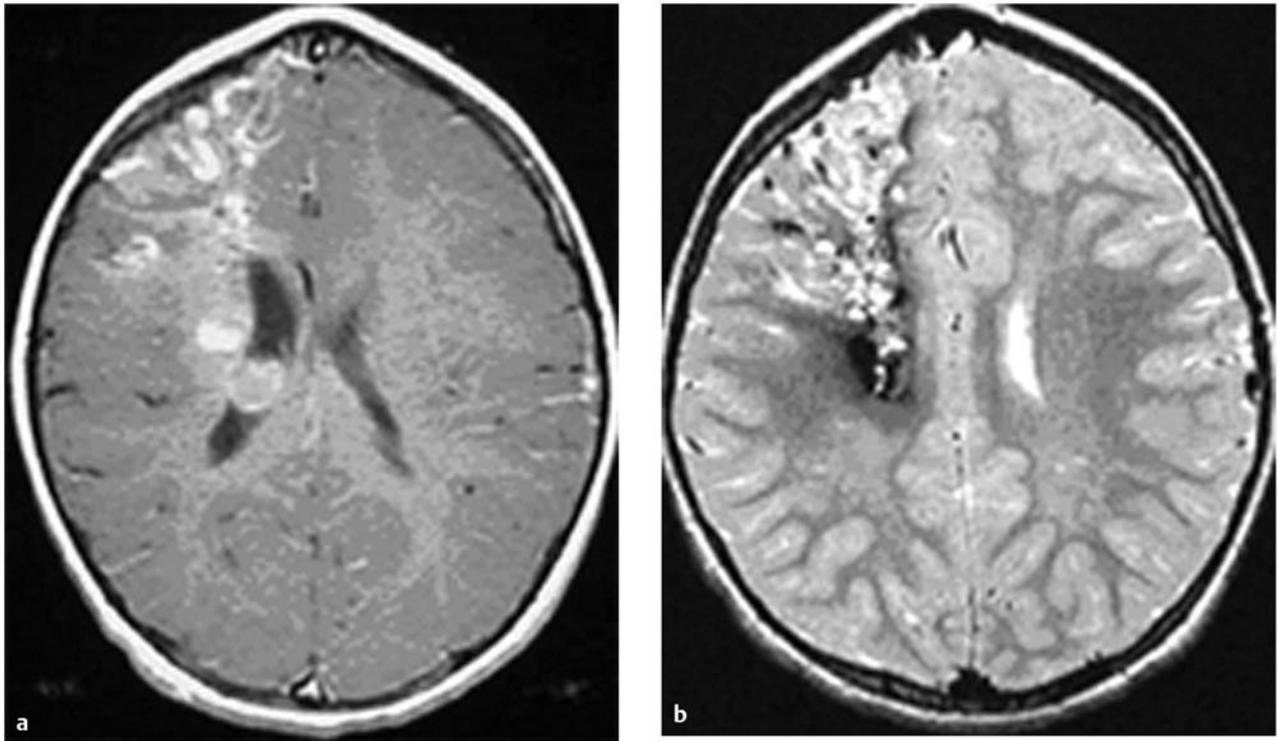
Magnetic resonance imaging studies. (a) T1 with contrast enhancement and (b) T2 demonstrating deep right posterior frontal cavernous malformations with an overlying wedge-shaped cortical venous anomaly and telangiectasia.
